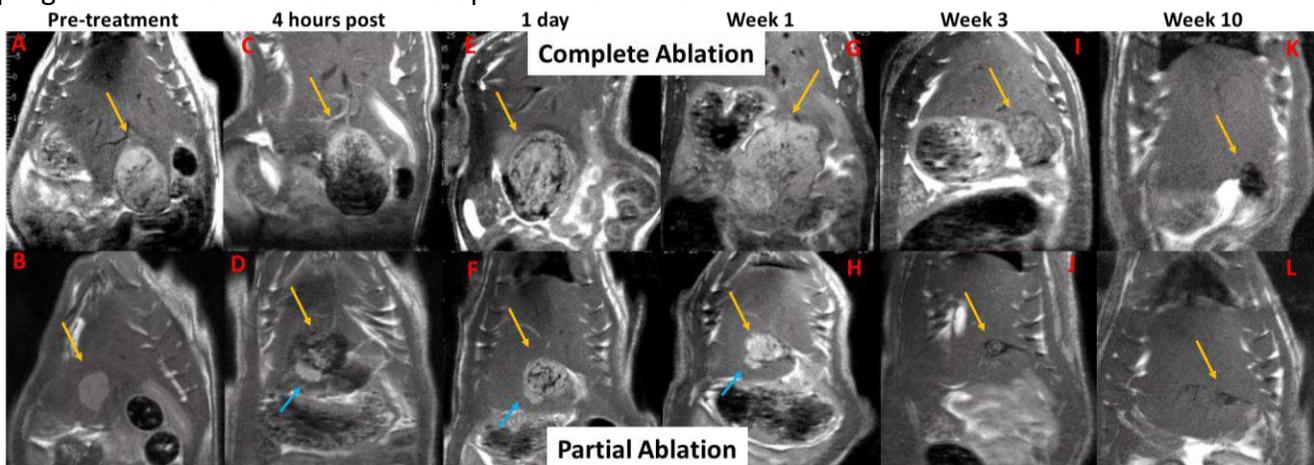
MRI demonstrated local tumor regression in complete and partial histotripsy (*non-targeted tumor, blue arrow*) cases without radiographic evidence of tumor by week 10. At week 10, T2-hypointense tissue at treatment site corresponded to gross non-tumoral, fibrous tissue.
